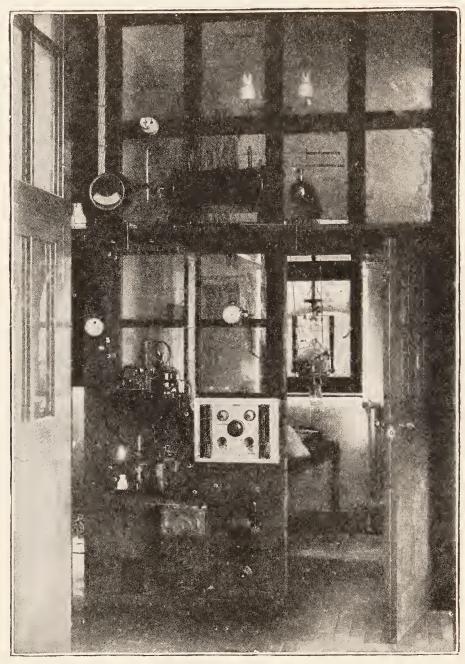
X-ray treatment cubicle. (Archives of Radiology and Electrotherapy.) Control apparatus arranged outside the cubicle.
